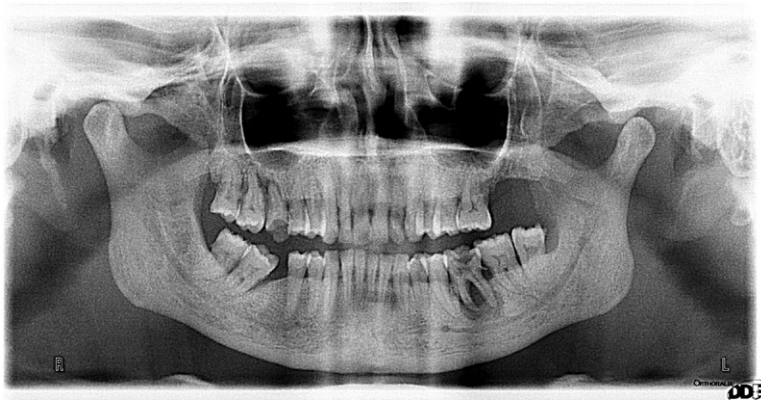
Panoramic radiograph showing “ground glass” appearance of renal osteodystrophy in a 44-year-old woman with a 10-year history of CKD due to focal segmental glomerulosclerosis on hemodialysis.
